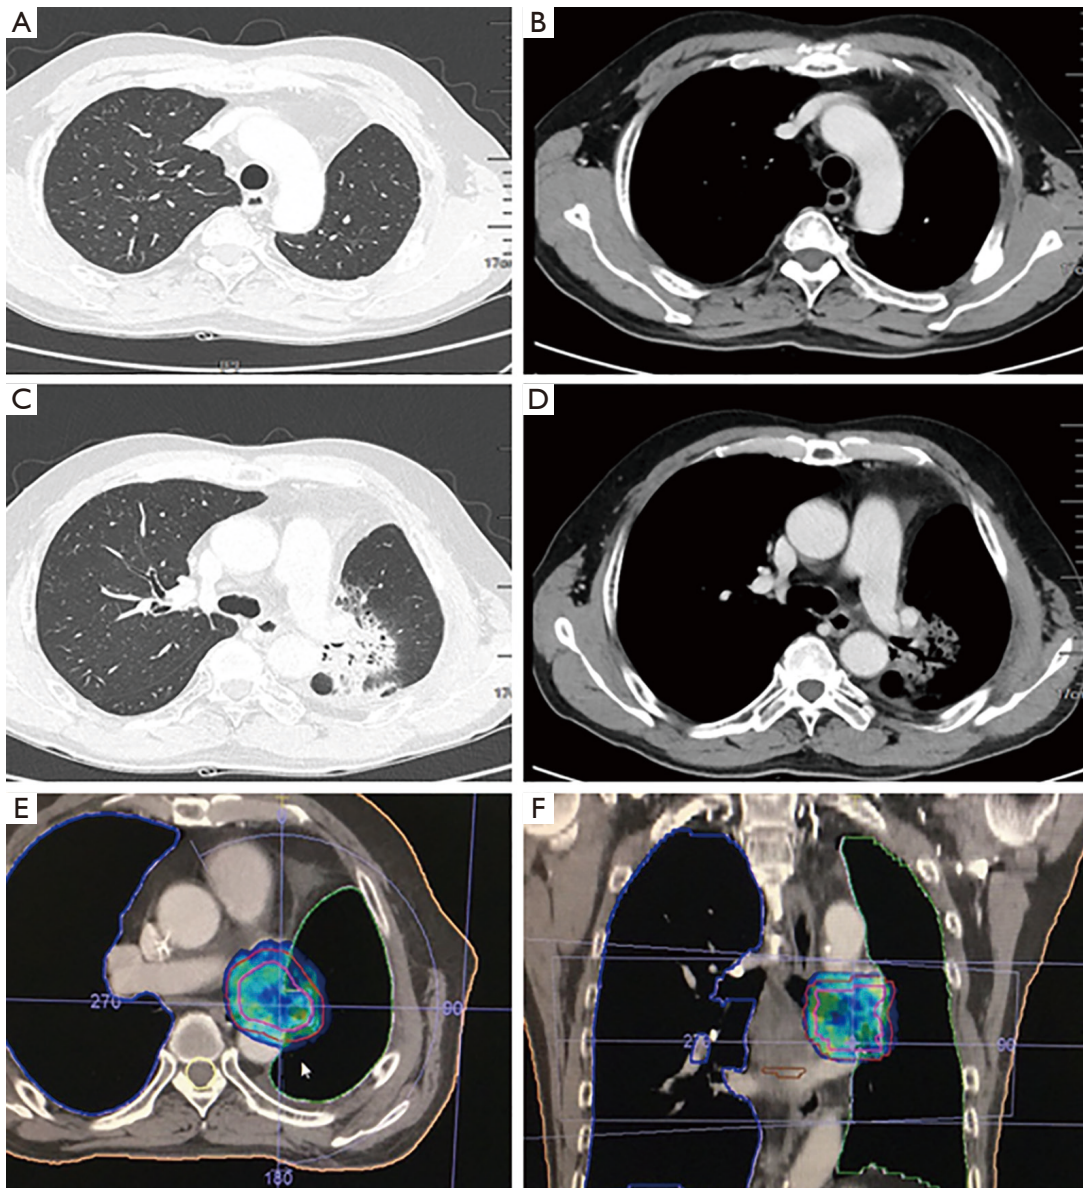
Radiation pneumonitis as a treatment-related adverse event. Follow-up after half a year, the image of lung window (A) and mediastina window (B) was showed in the surgical excision and the image of lung window (C) and mediastina window (D) was showed in the lesion of radiation pneumonitis. Horizontal position (E) and coronal position (F) scans were showed in chest CT.
